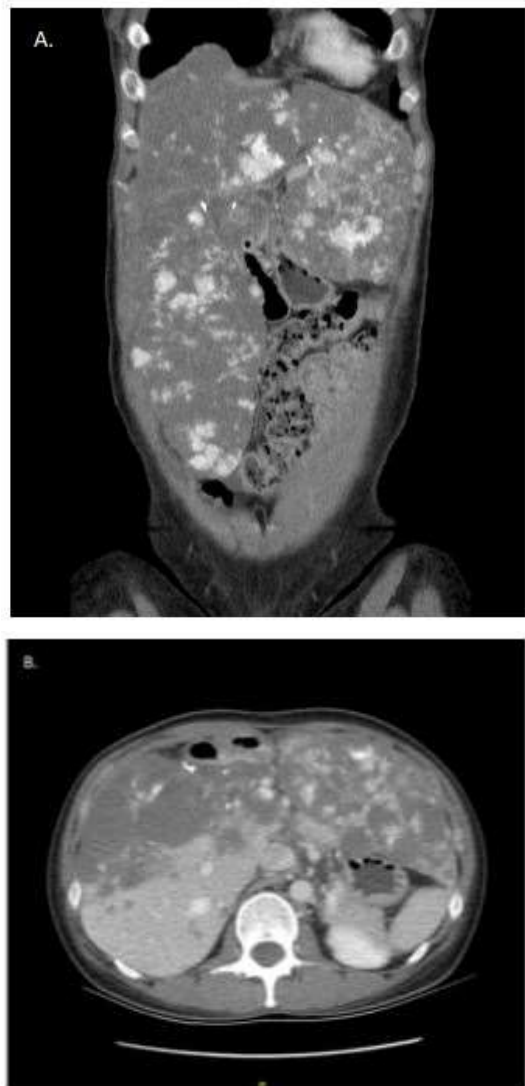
Contrast MRI of the abdomen in coronal plane (A) and axial plane (B) showing diffuse liver hemangiomas, replacing most of the normal parenchyma.
